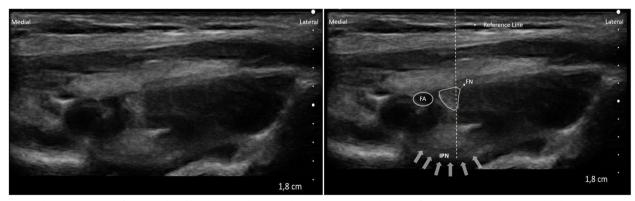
Ultrasound image of a 2-month-old baby boy 4.5 kg in weight and 56 cm in height. The reference line drawn between the skin and the iliopsoas notch passes over the femoral nerve. White arrows point to the iliopsoas notch. FA: femoral artery, FN: femoral nerve, IPN: iliopsoas notch
